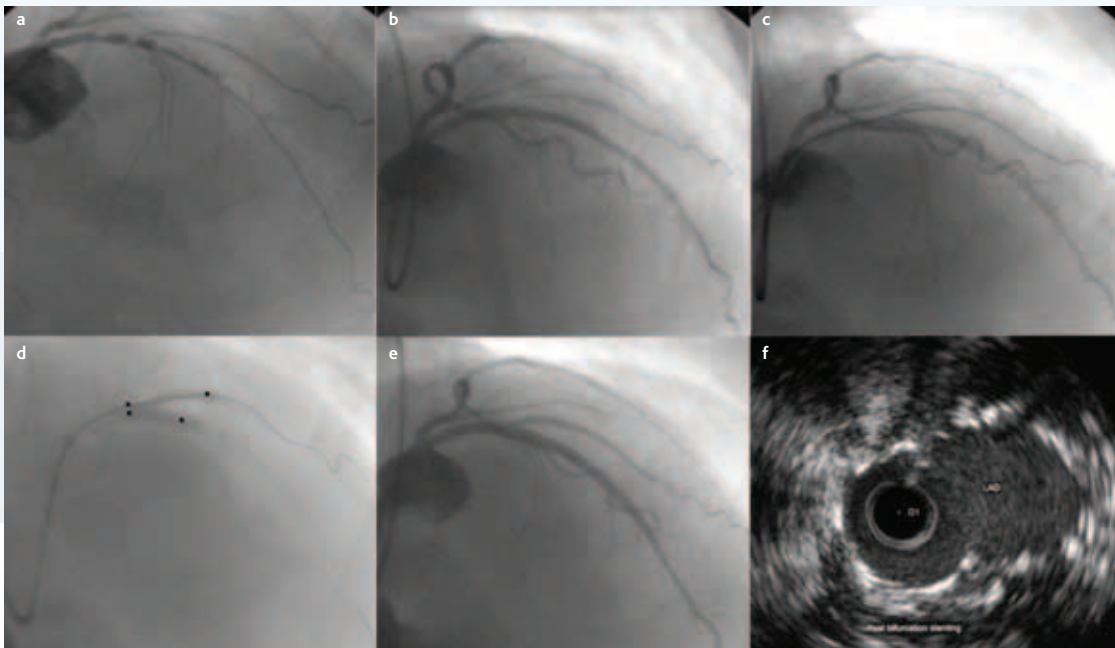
An example of the T-stenting with protrusion technique used to stent a flow-limiting dissection in the side branch after a provisional approach: (a) baseline angiogram showing diffusely diseased left anterior descending (LAD) artery with true bifurcation lesion of LAD/diagonal; (b) plaque shift and decreased flow in diagonal artery after stenting of LAD; (c) flow-limiting dissection in diagonal after balloon dilatation; (d) placement of Quantum™ (Boston Scientific, Natick, MA, USA) in LAD and Cypher® (Cordis Corporation, Miami, FL, USA) 2.5 x 18 mm stent in diagonal with slight protrusion of stent into LAD, followed by simultaneous inflation of both balloons (black dots are balloon markers); (e) final angiographic result; (f) intravascular ultrasound pull-back in diagonal confirming full coverage of ostium and 'figure of eight' appearance to LAD/diagonal.
